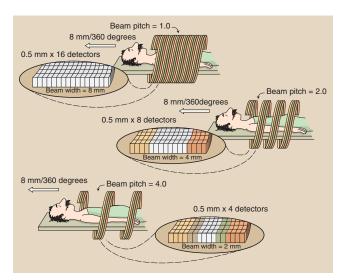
Pitch is patient couch movement divided by x-ray beam width.
